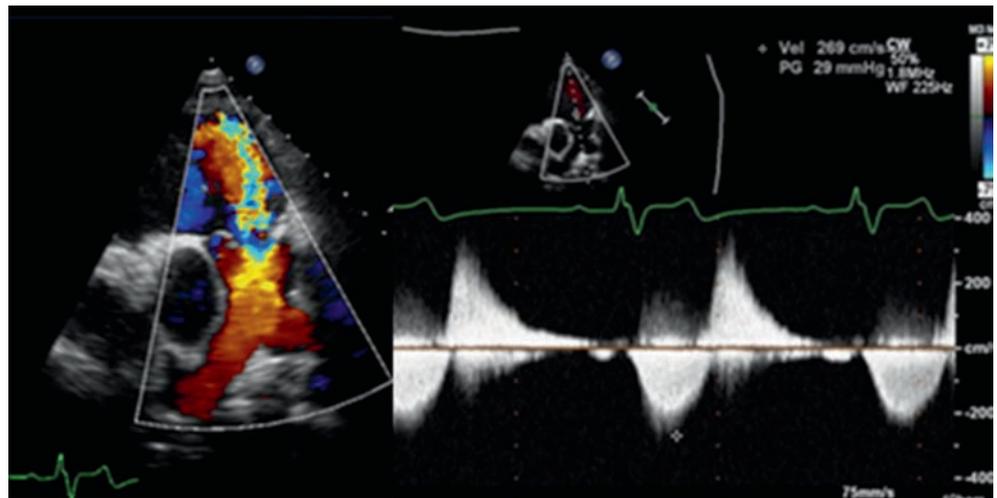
Tetralogy of Fallot. Post-operative image. Severe pulmonary regurgitation after tetralogy of Fallot repair. The *left panel* shows a diastolic frame with a wide regurgitant jet at valve level and backflow originating from distally into the pulmonary branches. The Doppler shows the short deceleration time typical for severe pulmonary regurgitation with flow only in early and mid-diastole
